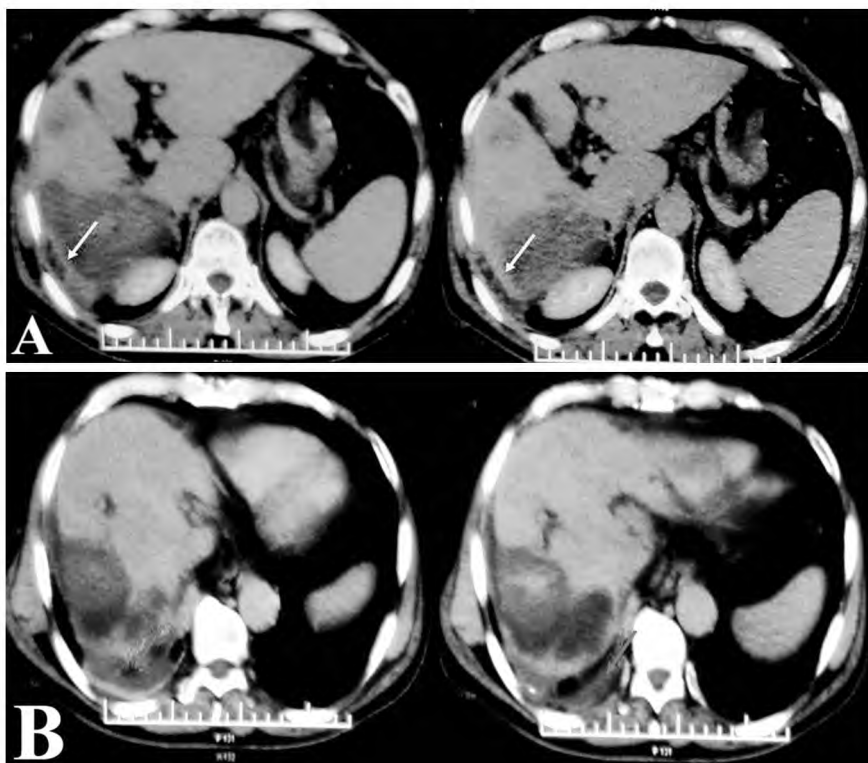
Male patient aged 67 years old with hepatitis C cirrhosis. A triphasic CT abdomen was done and revealed a single HCC at segment VI/VII. (A&B): Triphasic CT abdomen showing a well-defined hypo-dense non-enhancing focal lesion in the right lobe segment VI/VII, coping with completely ablated HCC with peri-hepatic fluid collection (Yellow arrow) and right-sided pleural effusion (Red arrow).
